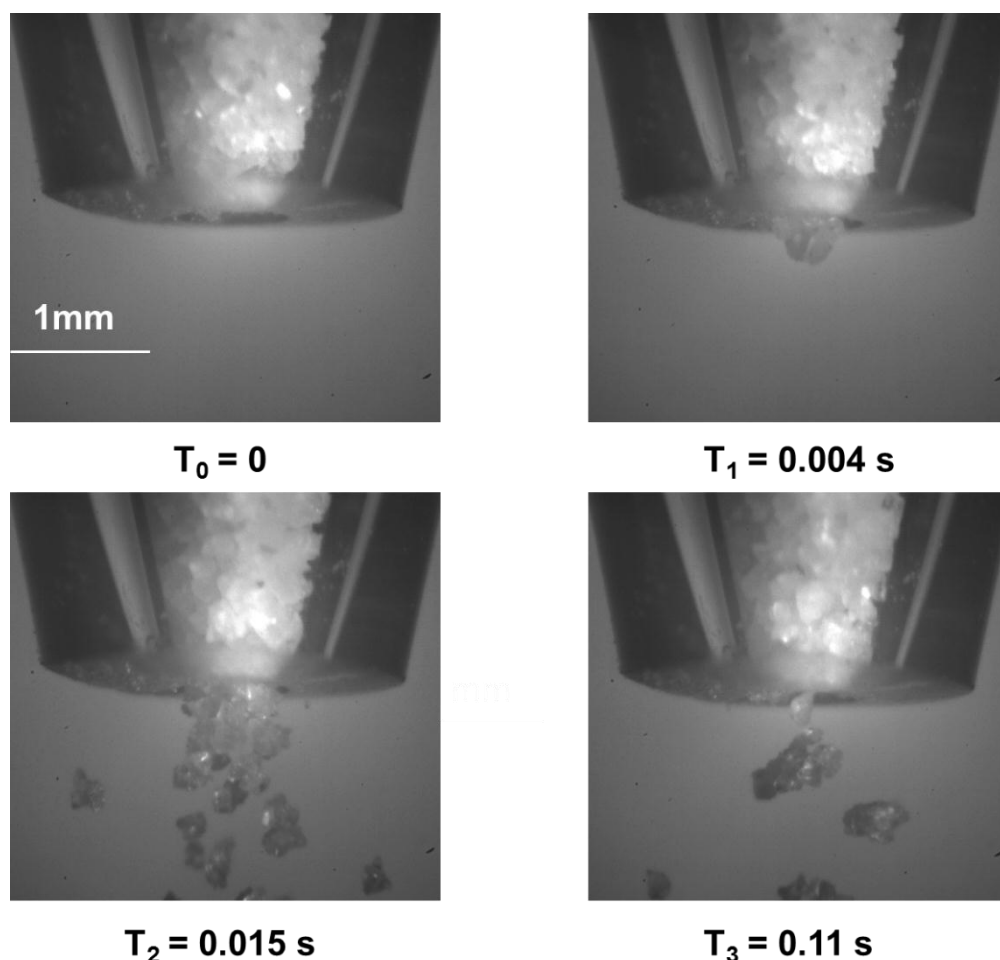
10 High speed video frames of InhaLac®70 from dispensing with ultrasonic vibration.
